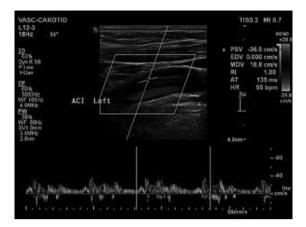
Suspicious dissection of the left internal carotid artery on the colour Doppler
